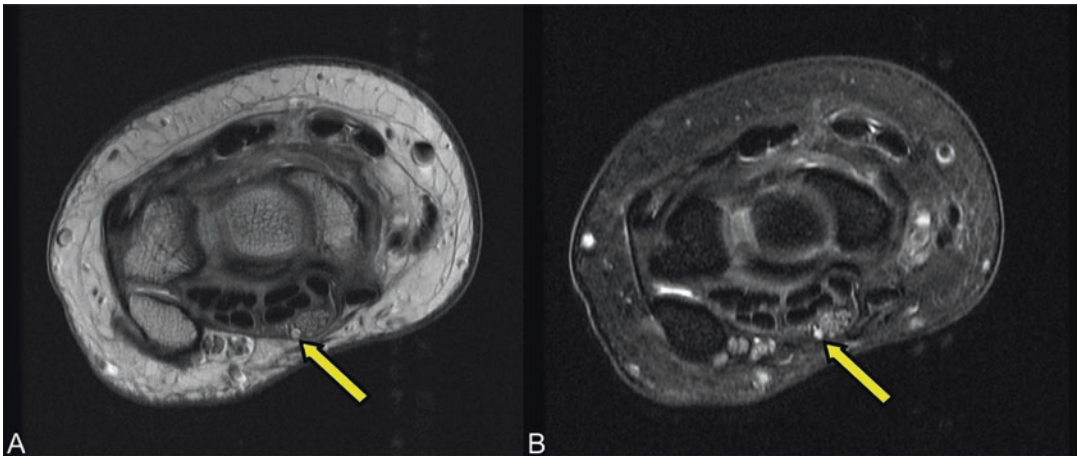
Axial MRI proton density (a) and T2 fat saturation (b) at the level of the pisiform—median nerve enlargement and high signal with variant vascular anatomy; persistent median artery (yellow arrow)
